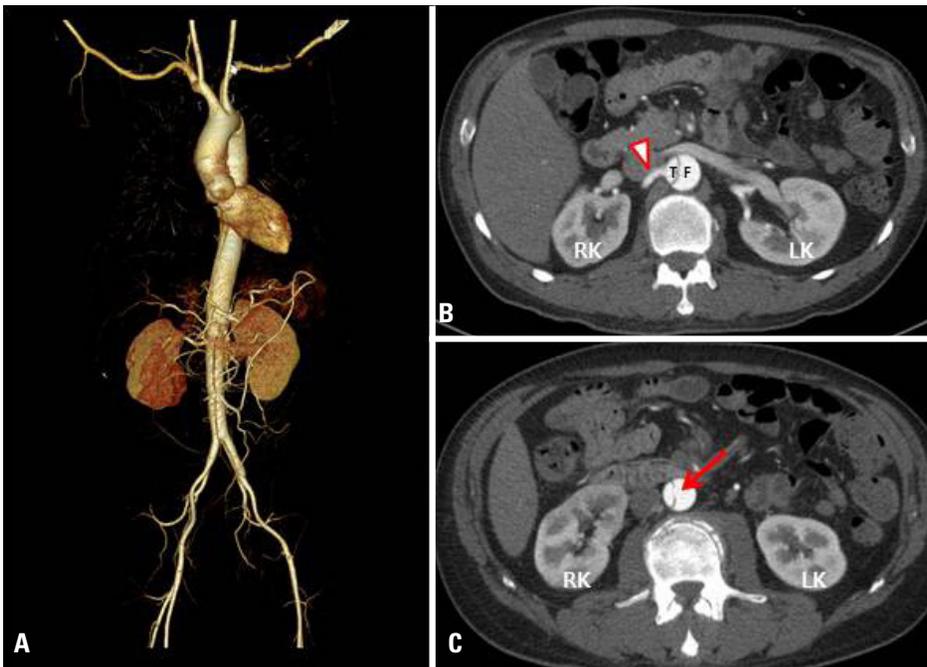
Follow-up CT at day 5 in (A) three dimensional reformations, and (B, C) axial views show widened true lumen with restored flow to the RK (arrowhead). Fenestrated septum is visualized (C, arrow). CT: computed tomography, RK: right kidney, LK: left kidney, T: true lumen, F: false lumen.
